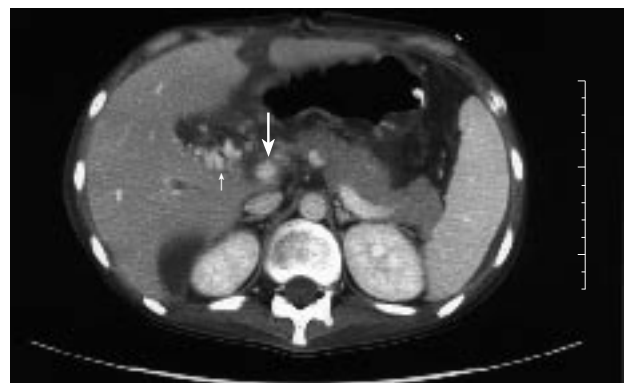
Computed tomography of the abdomen showing evidence of partial recanalization of the portal vein (long arrow) with increasing surrounding collaterals (short arrow).
